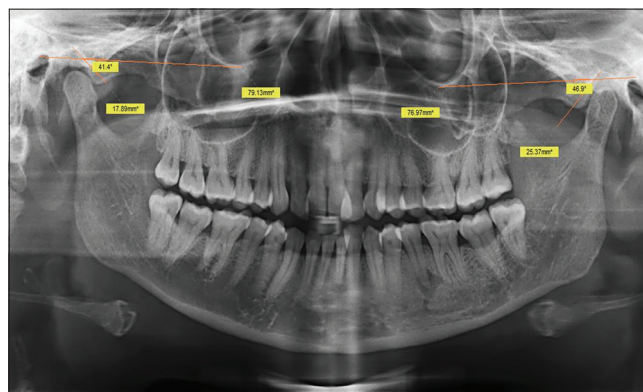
Panoramic radiograph of dentulous patient showing the tracing of the articular eminence inclination
